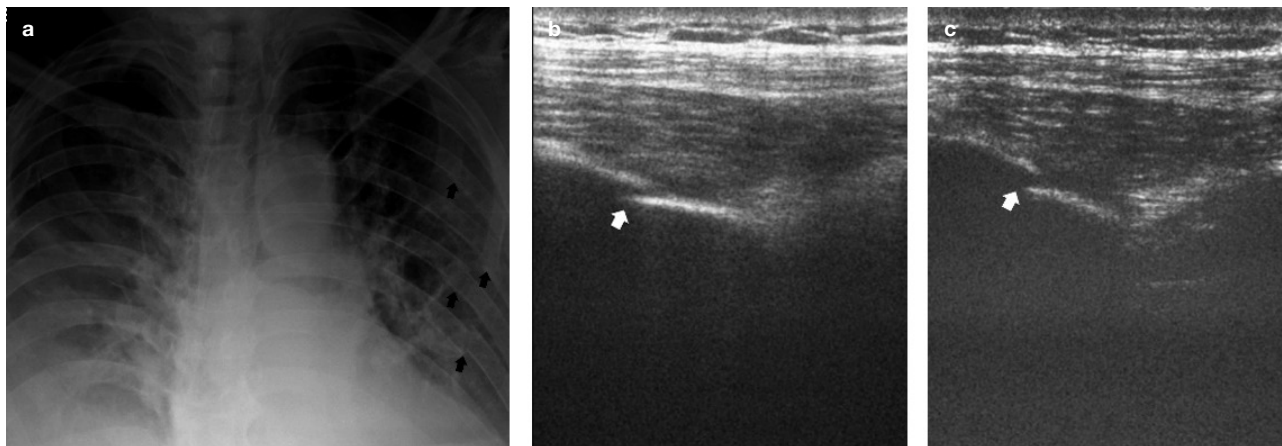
Chest X-ray and US image of a patient with serial rib fractures on the left side. Arrows indicate fracture areas where cortical continuity is lost
